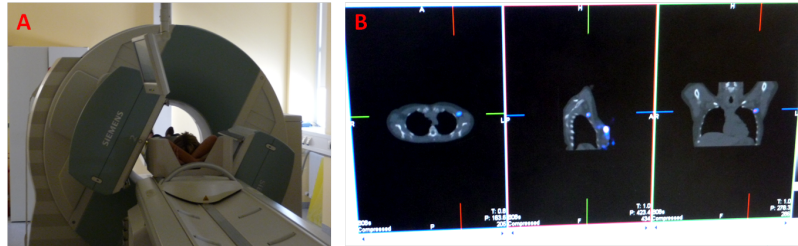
Preoperative SPECT/CT at TUM. (A) SPECT/CT is acquired with arms behind head. (B) Reconstructed 3D images are then visualized in all three slices.
